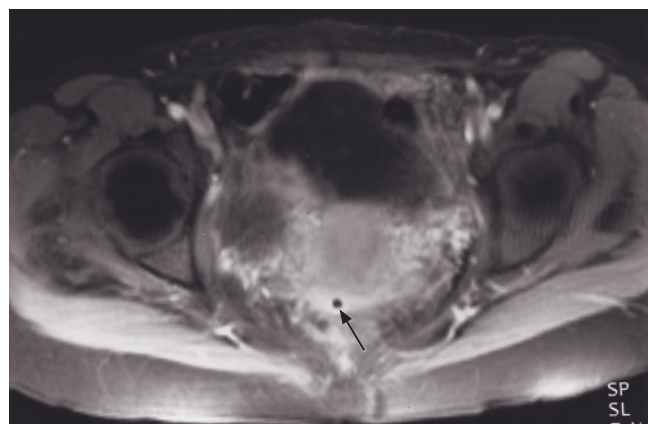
Pelvic abscess, before and after catheter drainage. Sagittal 512-resolution T2-weighted echo-train spin-echo (a) and sagittal (b) and transverse (c) interstitial-phase gadolinium-enhanced fat-suppressed SGE images. The sagittal images demonstrate a 5-cm abscess in the pouch of Douglas (long arrow, a, b) and a smaller midabdominal abscess (short arrow, a, b). On the T2-weighted image, heterogeneous low signal is present in the dependent portion, which is a common finding in abscesses. On the postgadolinium images, substantial enhancement of the abscess wall and the adjacent rectum (open arrow, b) is present. Multiple Nabothian cysts are present in the cervix (small arrow, a, b). The transverse gadolinium-enhanced fat-suppressed image through
